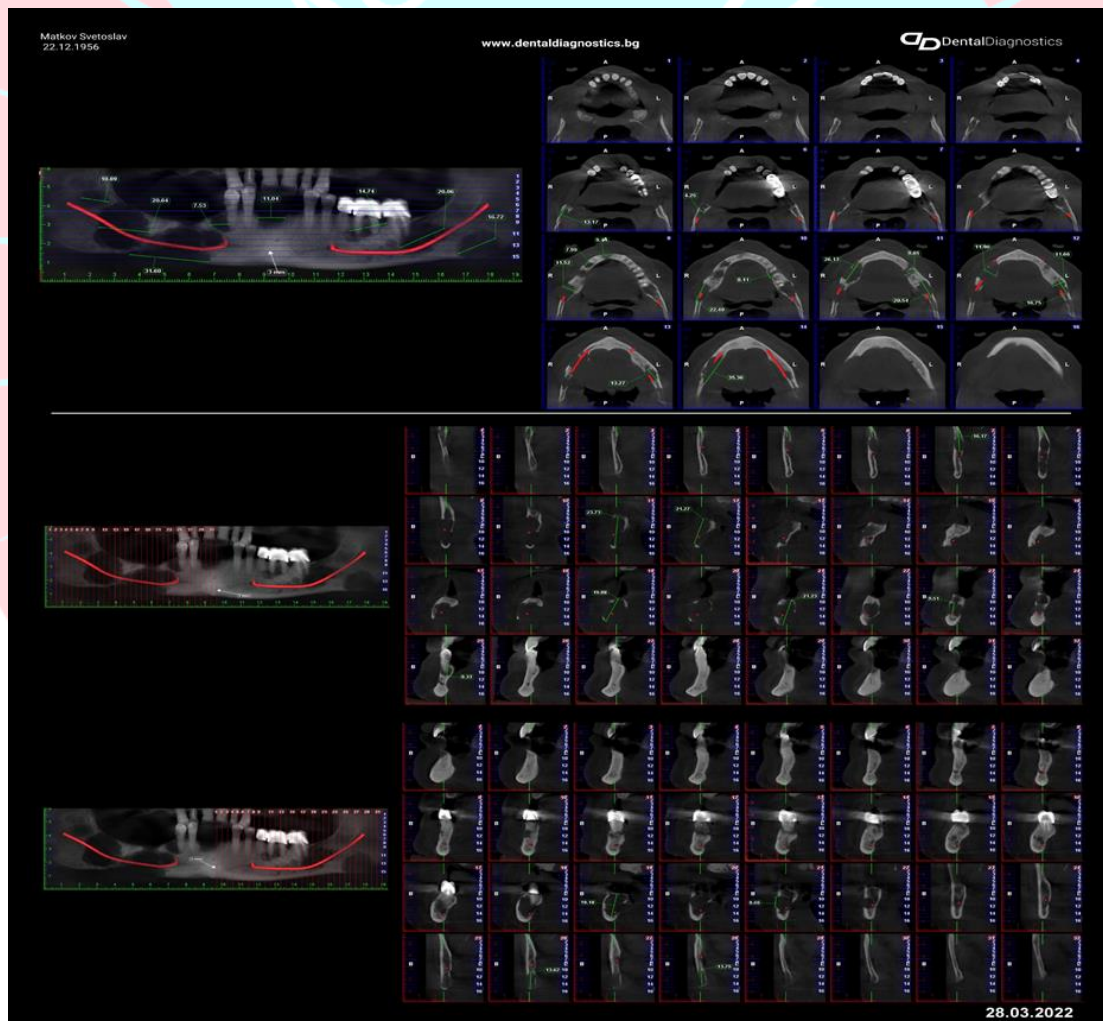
CBCT of the mandible 03.2022. Osteolytic lesions are clearly visible
